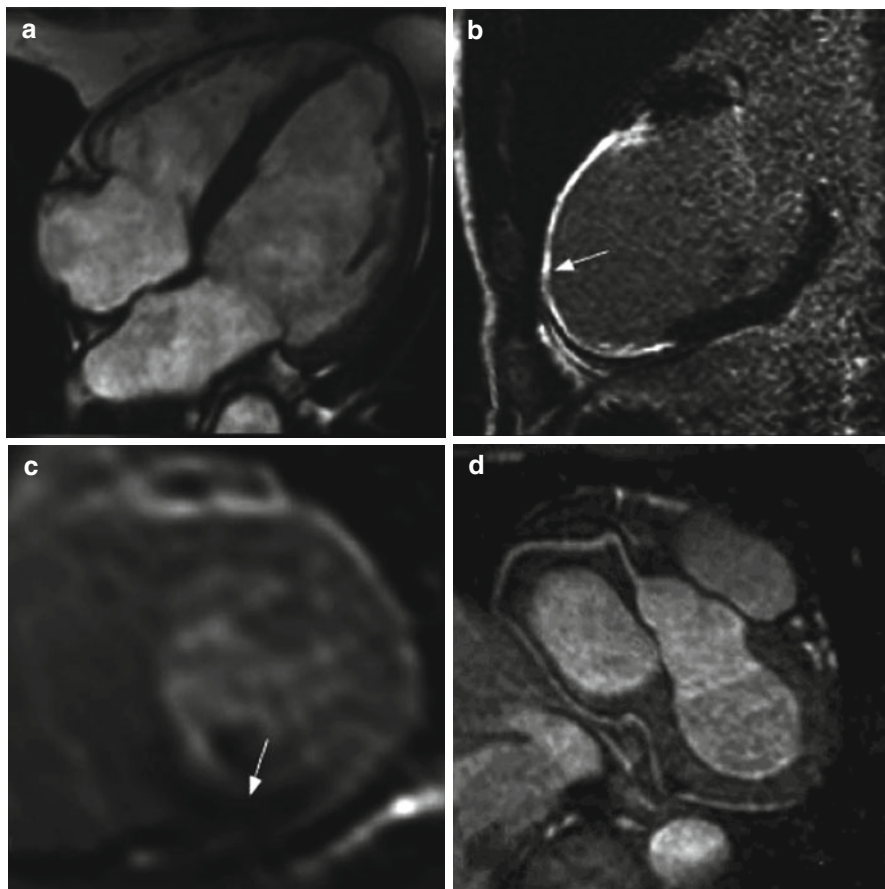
Cardiac magnetic resonance imaging. Sample cardiac MR images. (a) Standard four-chamber SSFP view of the heart LV showing both atria and ventricles. (b) Vertical long-axis late gadolinium enhancement view of the LV showing infarction of the anteroapical wall (*arrow*). (c) Short-axis view of the LV showing a perfusion defect in the inferior wall (*arrow*). (d) Typical MR angiogram of a right coronary artery (From Greenwood et al. [10]; © 2009; licensee BioMed Central Ltd.<http://www.trialsjournal.com/content/10/1/62>)
